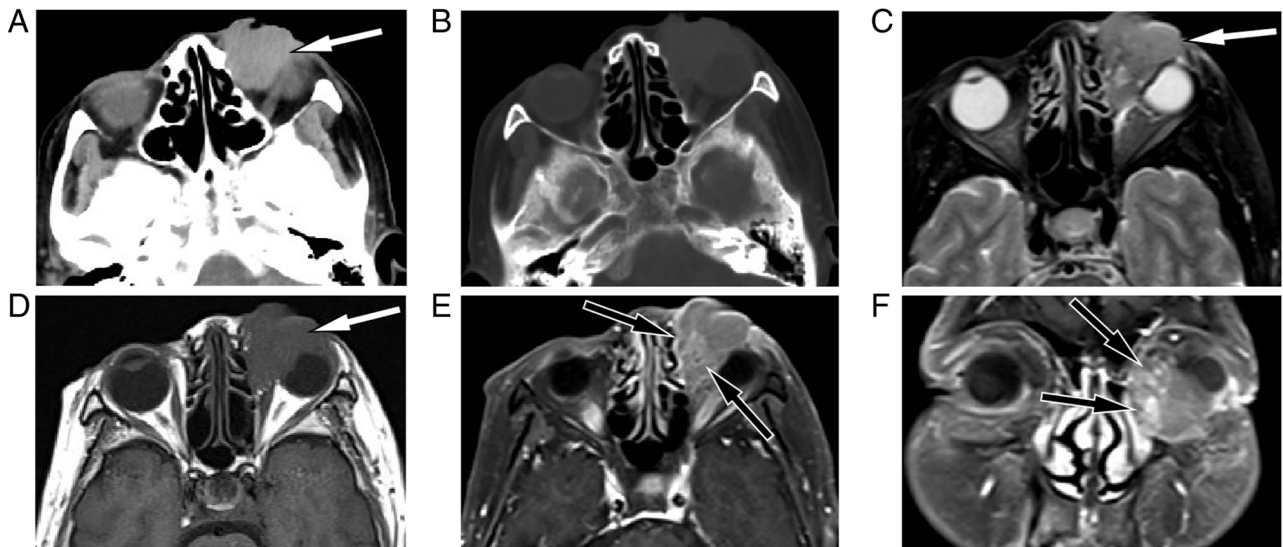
(A) Head CT showed a slightly hyperdense mass measuring $\sim 2.8 \times 2.4$ cm outside the left orbital muscle cone (white arrow), and the left eyeball showed pressure changes. (B) The CT bone window showed no obvious signs of bone resorption or bone destruction in the adjacent bone. (C) T2WI sequences of magnetic resonance imaging showed the lesion to be slightly hyperintense (white arrow). (D) T1WI sequences showed the lesion to be of equal signal with soft tissue (white arrow). (E) Axial and (F) coronal contrast-enhanced T1WI sequences showed inhomogeneous enhancement of the lesion, with markedly enhanced tortuous vascular shadows (black arrows) seen within the tumor tissue. CT, computed tomography; WI, weighted imaging.
